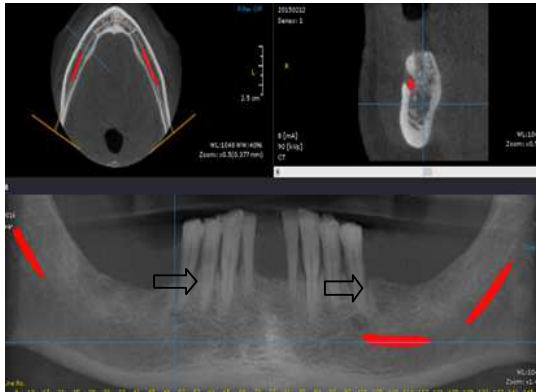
location of inferior alveolar canal and mental foramen (CBCT and panoramic view).
